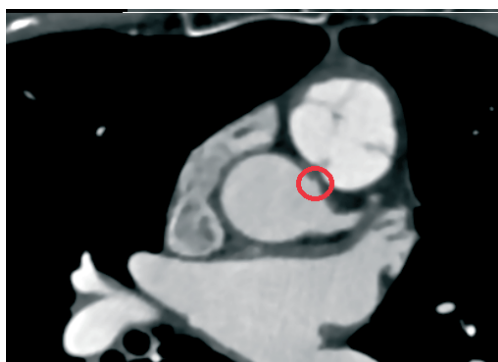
Coronary computed tomography angiography image of anomalous origin of right coronary artery from left sinus of Valsalva with inter-arterial course between aorta and pulmonary artery
